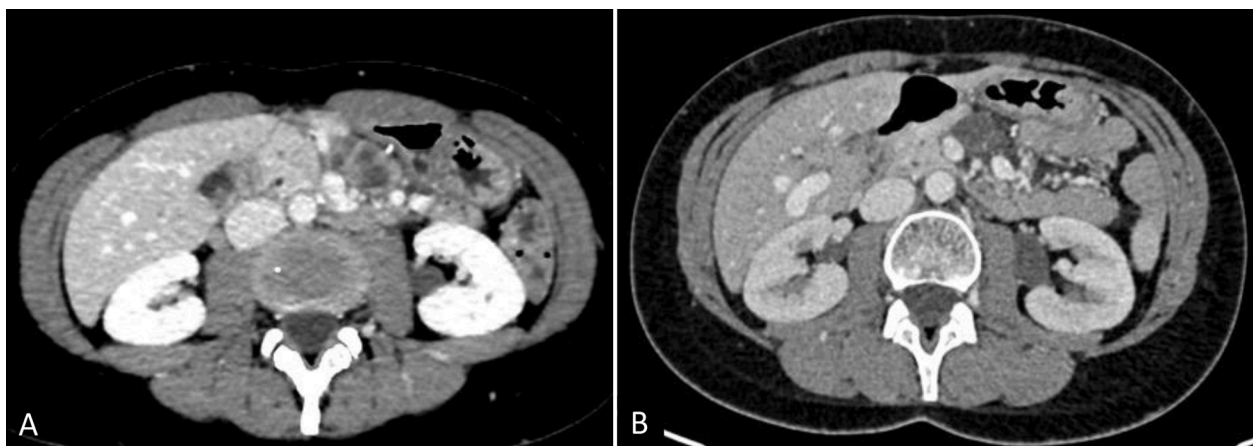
(A) Axial contrast-enhanced computed tomography (CE-CT) image shows confluent lymphadenopathies with mixed peripheral enhancement and focal central necrosis in the root of mesentery. (B) Axial CE-CT image shows the same lymphadenopathies completely necrotic one month after the end of treatment.
